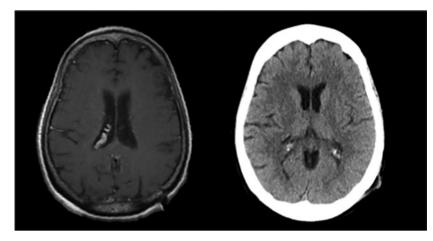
(Left) Axial contrast-enhanced MRI of the brain and (right) axial noncontrast CT of the head showing no abnormality.
